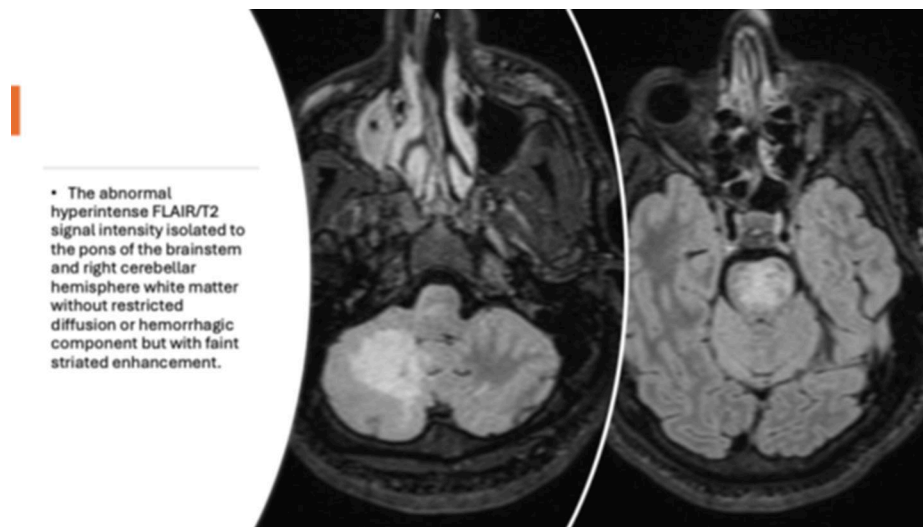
MRI scans demonstrating T2/FLAIR hyperintense lesions in the pons and right cerebellar hemisphere.
